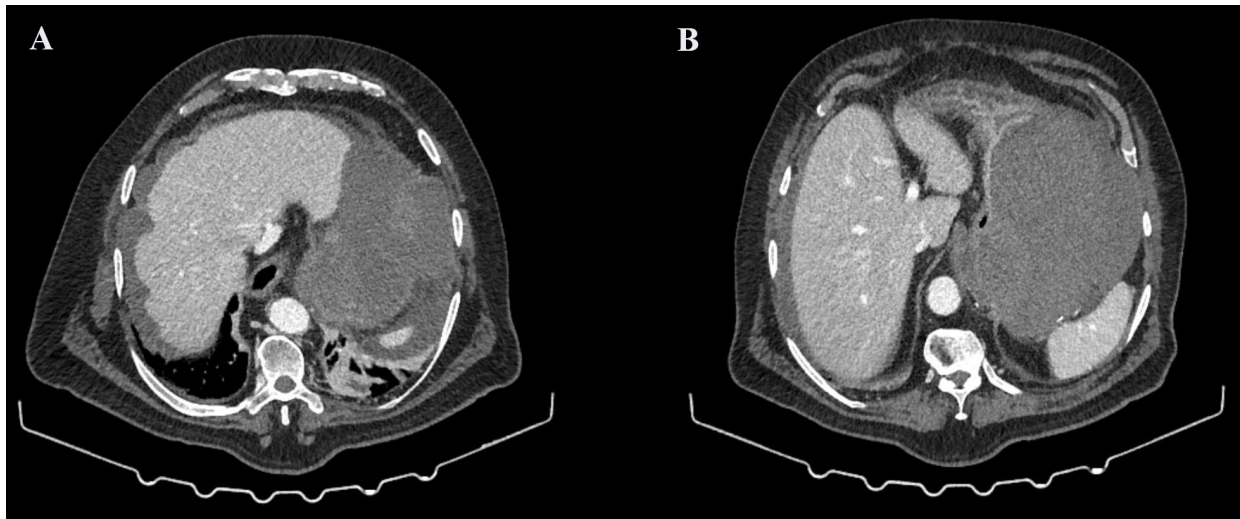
Axial abdominal thoracoabdominopelvic computed tomography (CT) angiography images demonstrating a large intraluminal mass approximately 16×12 cm in size, markedly distending the gastric lumen, with an intraluminal hyperdense collection consistent with hemorrhage. (A) Upper-level axial section showing the mass filling the gastric lumen. (B) Lower-level axial section demonstrating the extent of the lesion.
